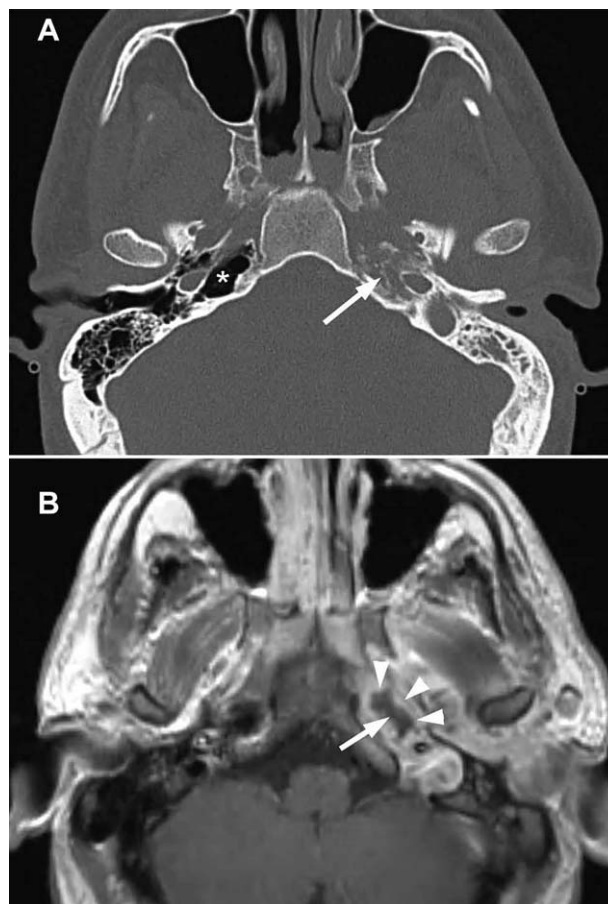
(A) CT scan. Arrow shows a left infected opacified petrous apex with disruption of bony trabeculae. Right petrous apex is pneumatized (*). (B) MRI with gadolinium shows rim enhancement (arrow-heads) of inflamed lining with central necrosis within petrous apex. CT = computed tomography; MRI = magnetic resonance imaging.
